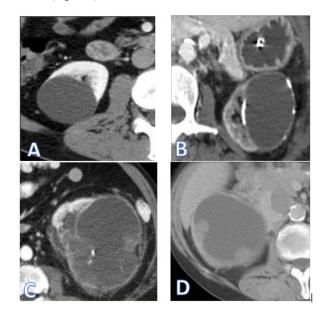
Figure I CT images of renal cysts according to Bosniak's classification.
